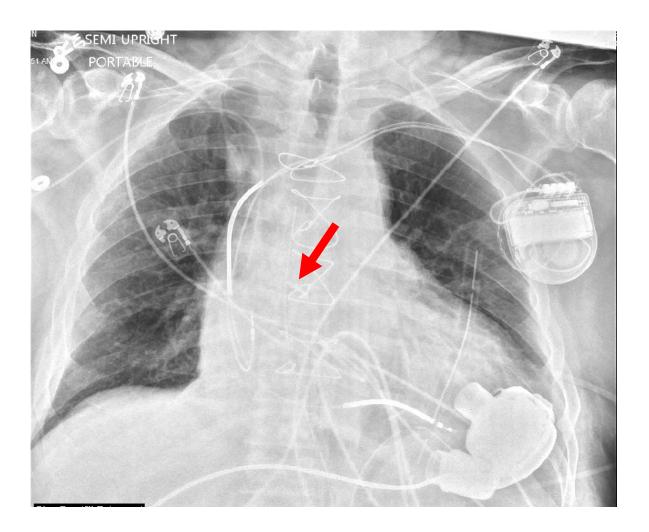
Measurement Method on Anteroposterior and Lateral Chest Radiograph. Radiopaque marker (two standard surgical clips) on the anterior surface of the aorta is positioned halfway between the sino-tubular ridge of the aorta and the right coronary artery (Red Arrow). Black line indicates center line of the HeartMate 3 inflow canula. The dotted red line indicates the degree of deviation from the reference point (surgical radiopaque marker).
